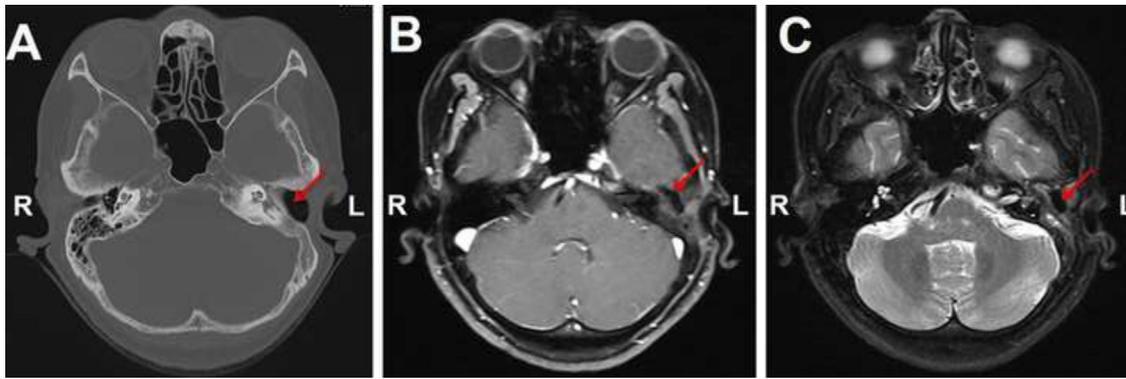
CT with bone windows, contrasted T1-weighted MRI and T2-weighted MRI of the temporal bone obtained at A: twenty-four; B,C: and seven months postoperatively. The red arrows indicate the lesion site.
